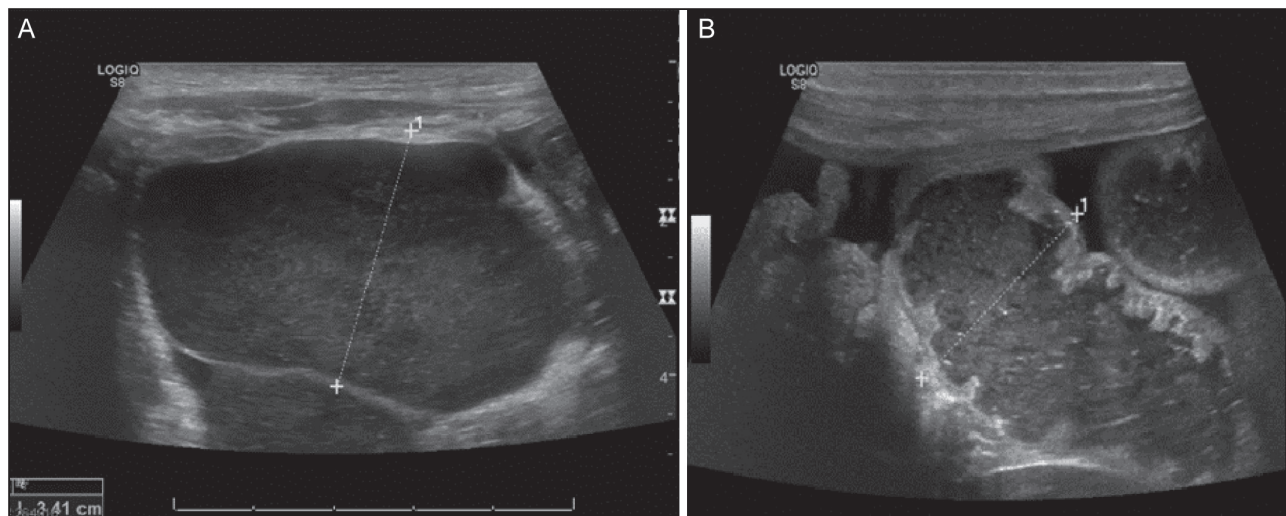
(A) Ultrasonography showing large cyst. (B) Ultrasonography showing dilatation of the bowel loops associated with thickening of its wall
